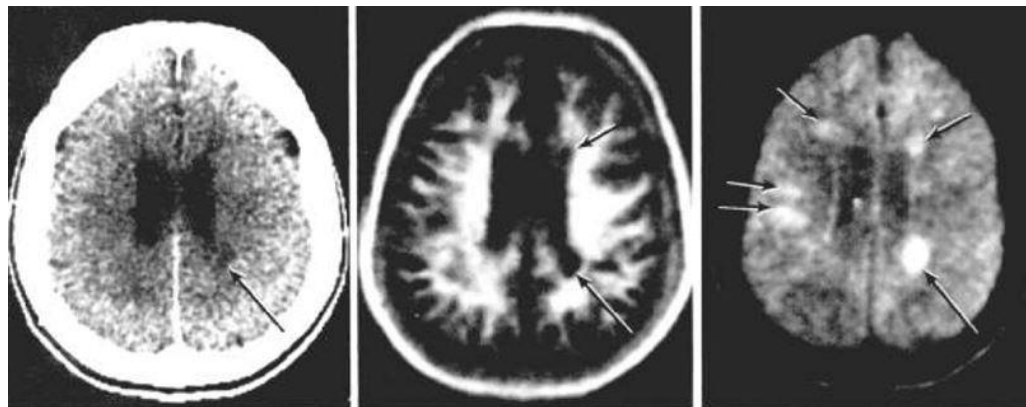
Multiple Sclerosis: CT (left), IR (centre) and SE (right) images. One lesion (plaque) is seen as a low signal (dark) region on the CT scan (arrow), several are seen as dark regions on the IR image (e.g. arrows) and at least five are seen as high signal (light) regions (e.g. arrows) on the SE image.
